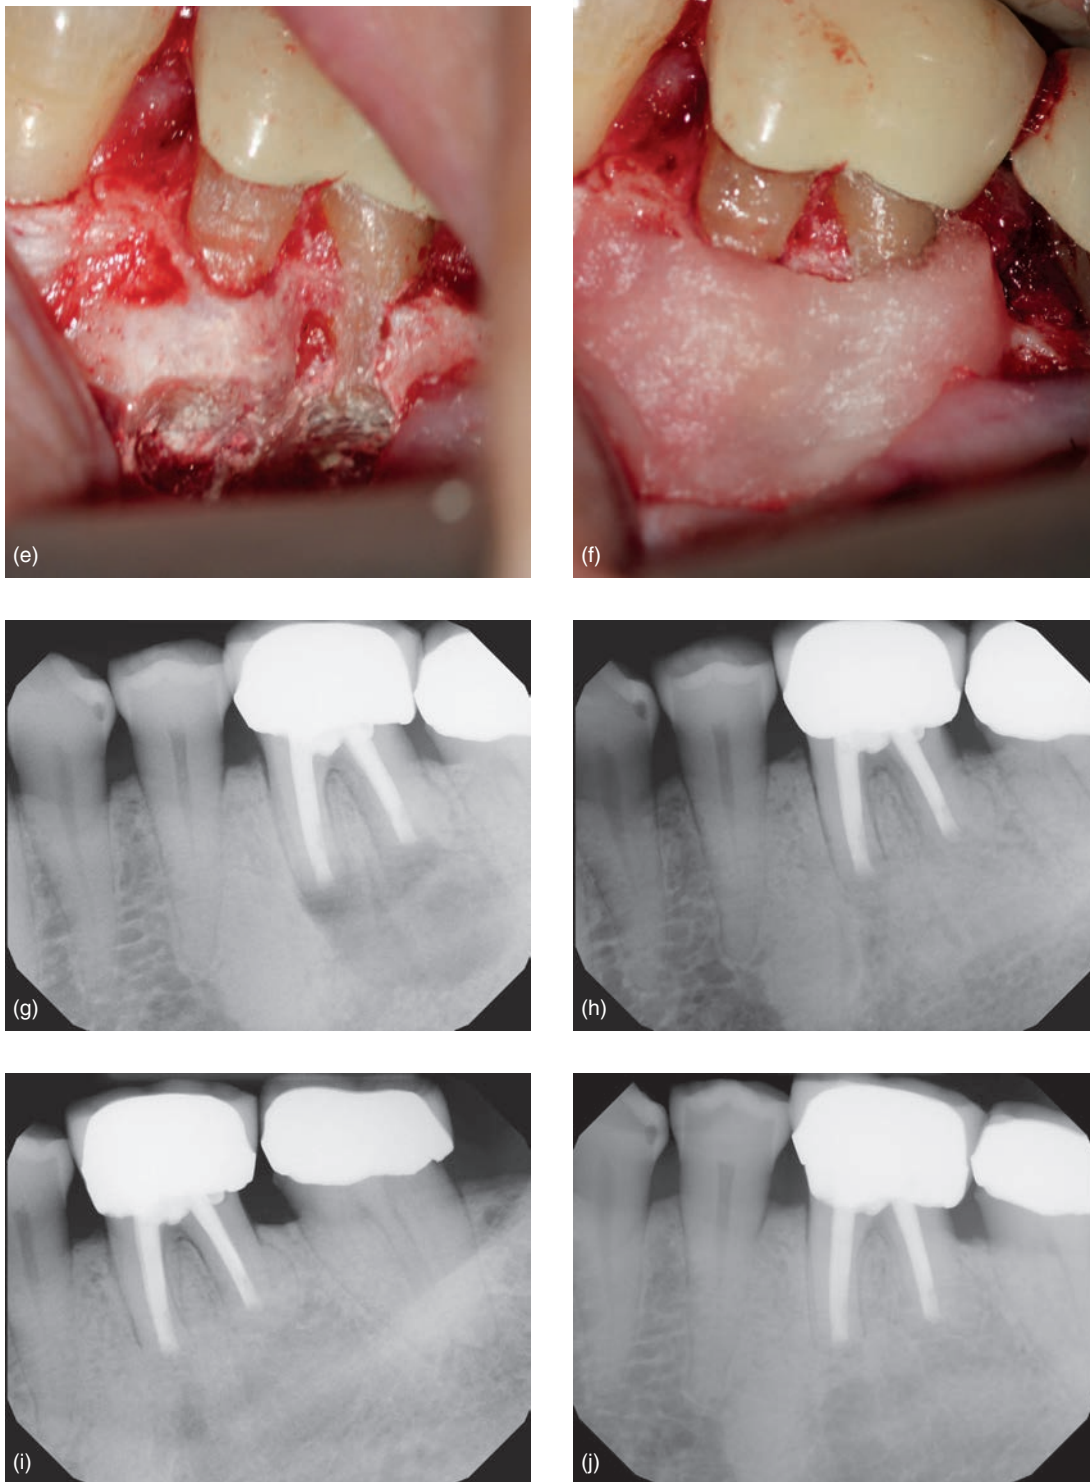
(Continued) (e) Bioceramic root end fillings; (f) foundation placed in crypt (not shown) and osteotomy covered by Collacote membrane; (g) postop radiograph; (h) 8 month follow-up; (i) 15 month follow-up; (j) 2.5 year follow-up.
